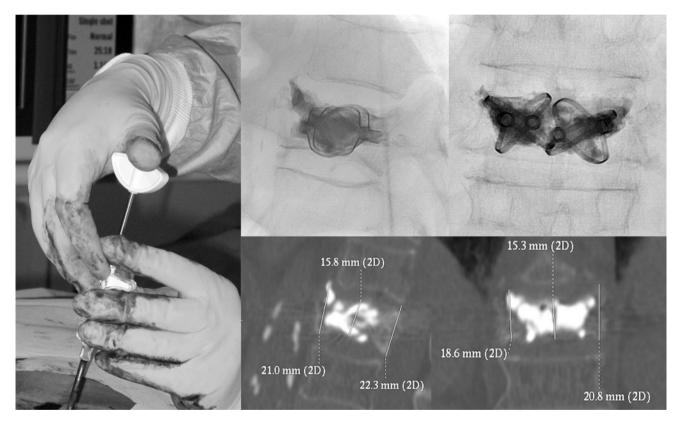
PMMA injection. Prefilled cannulae with blunt-tip pusher and the nitinol implants encased in bone cement. CT multiplanar reconstruction was performed for height measurements after implant expansion and PMMA injection
